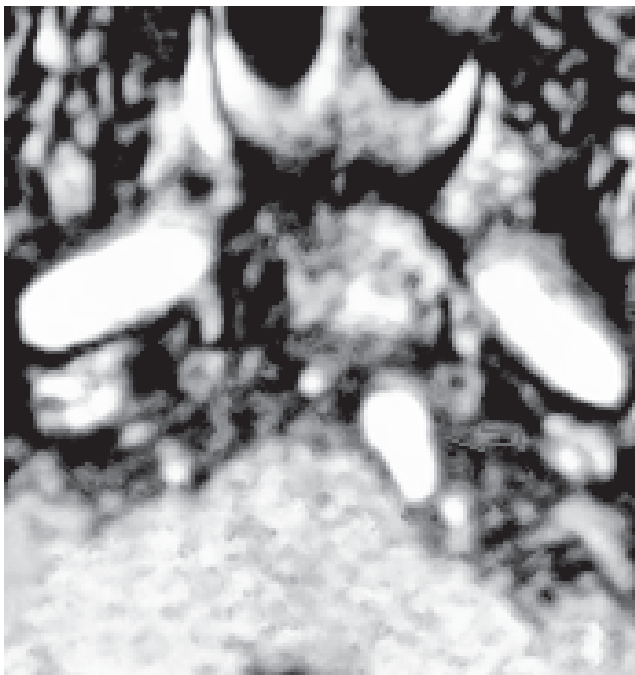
Axial TOF MR image.
